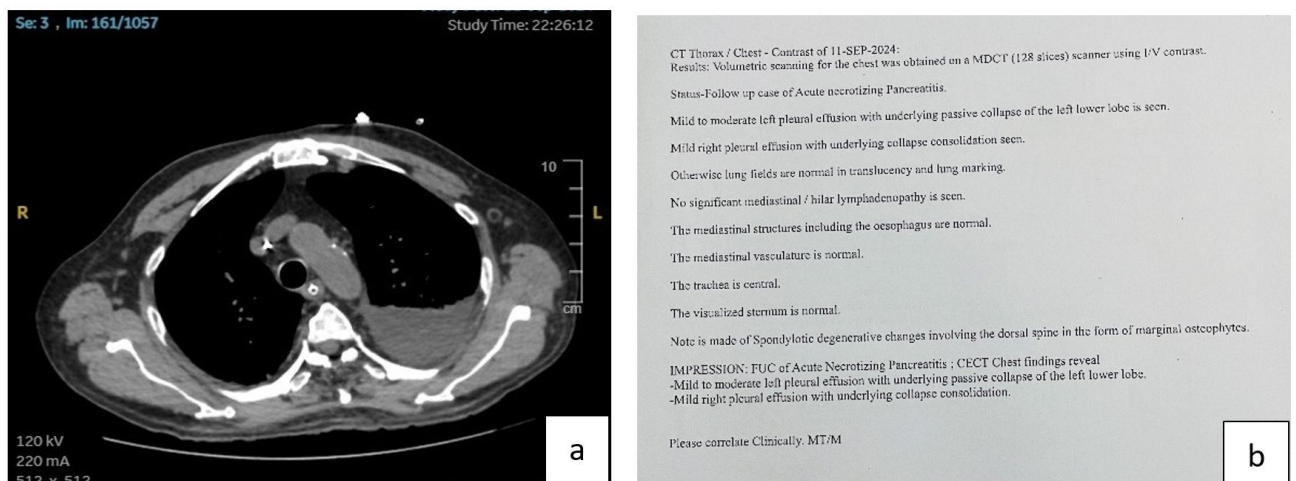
(a) Image, (b) report of CT- Thorax- showing- mild to moderate left sided pleural effusion with underlying passive collapse of the left lower lobe. Mild right sided pleural effusion with underlying collapse consolidation was also noted.
